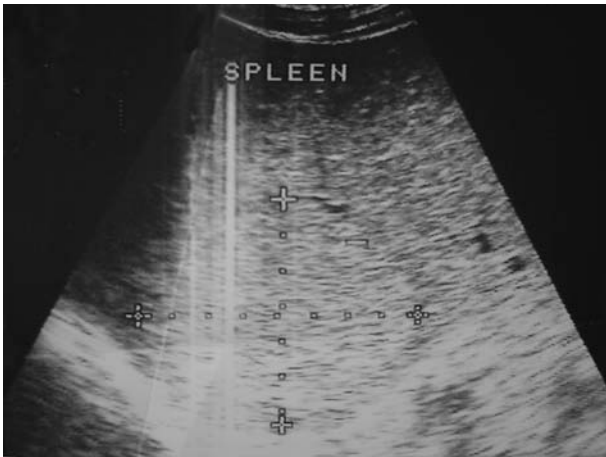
Ultrasonography at splenic level reveal an uniformly hyperechoic, well-margined oval lesion in spleen.
